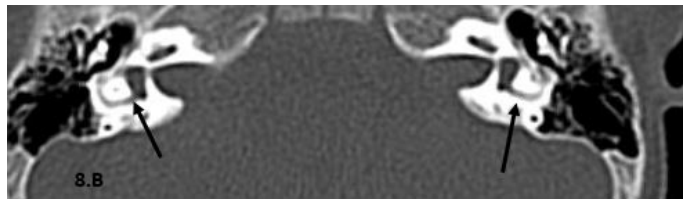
B: axial CT view revealed normal bilateral vestibules (black arrows).
